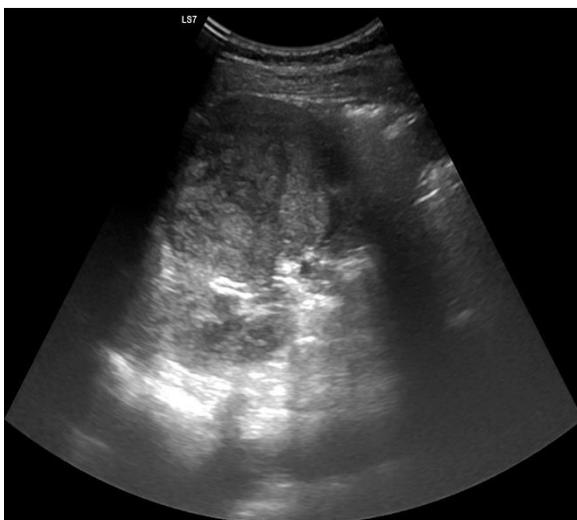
a) Grey-scale US: left renal mass b) Colour-Doppler US: hypervascularized tumor
